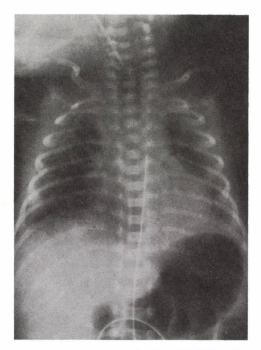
S.T. (Patient No. 3. of Table II/A). The X-ray made 24 hours after the administration of Curosurf shows that the lungs are pneumatized, the air bronchogram and the reticulogranular pattern disappeared. (Görgényi)
